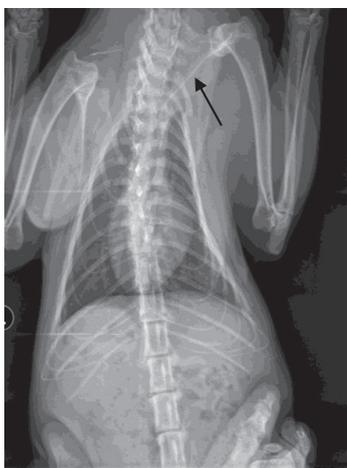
Radiographic image showing left scapulothoracic luxation with dorsal displacement (black arrow) and left scapula and left thoracic ribs with no signs of fracture
